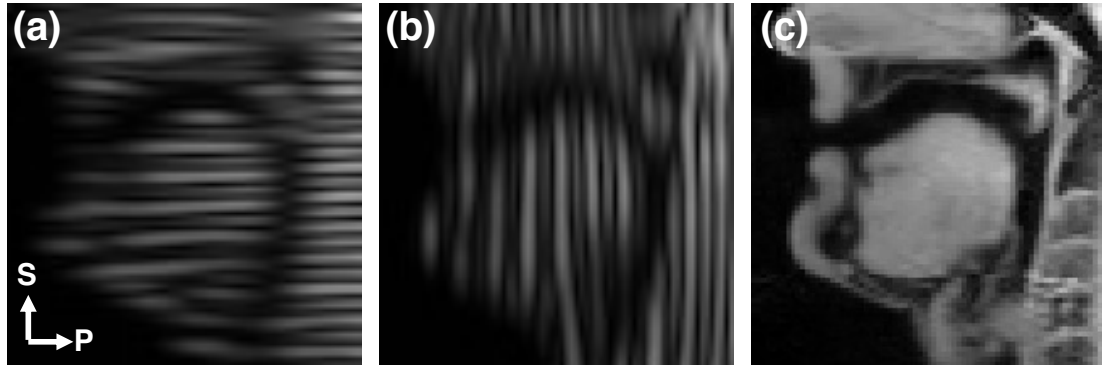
(a) Mid-sagittal slice of a horizontal tagged MRI of a human tongue. (b) Mid-sagittal slice of a vertical tagged MRI of a human tongue. (c) Mid-sagittal slice of a cine MRI of a human tongue.
